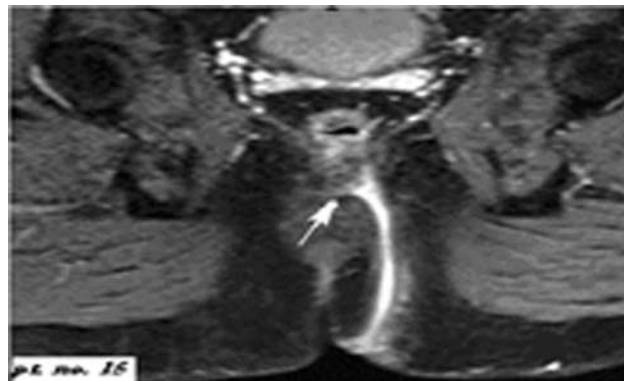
MRI misclassified a transsphincteric fistula as extrasphincteric one.
